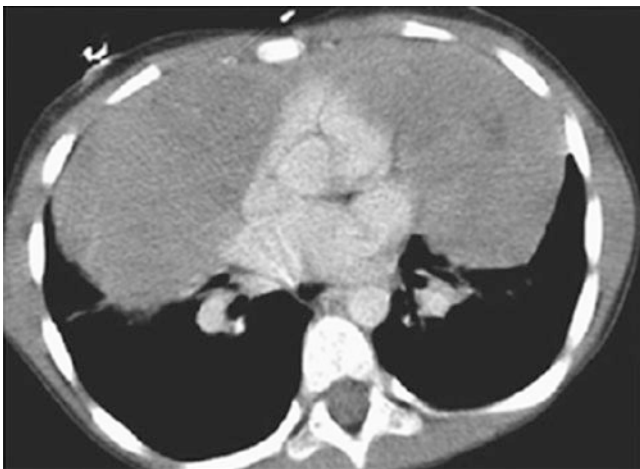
A 5-year-old boy with a large invasive thymoma who presented with persistent cough. Enhanced axial CT image demonstrates a very large, heterogeneous pleural mass draped over the heart
